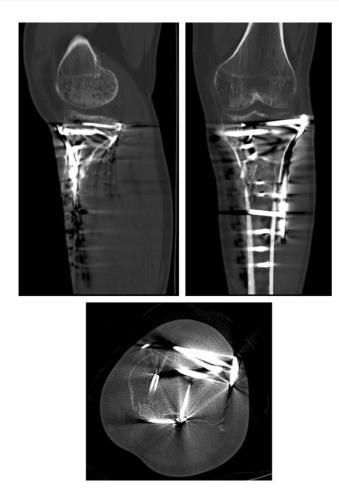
Control CT scan showing adequate joint reduction and signs of advanced consolidation of a Schatzker-VI tibial plateau fracture.
